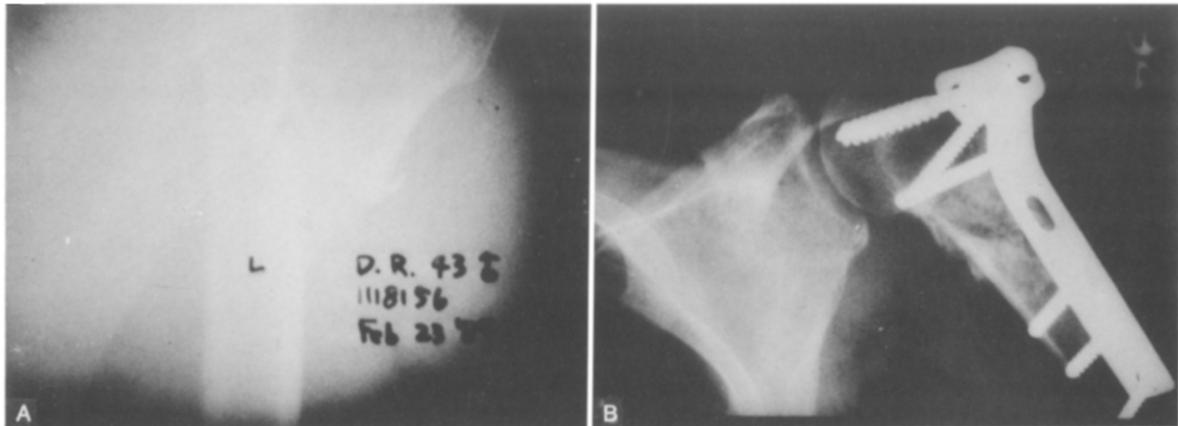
Forty-three-year-old man who was injured by motor vehicle accident. He had associated injuries including straddle fracture of pelvis, and grade II open fracture of left tibia. Operative treatment was selected to improve mobility. A, Initial anteroposterior radiograph shows surgical neck fracture with medical displacement of shaft. B, Anteroposterior radiograph, made 2 months after surgery shows good fixation with T-plate and screws and early callus formation.
